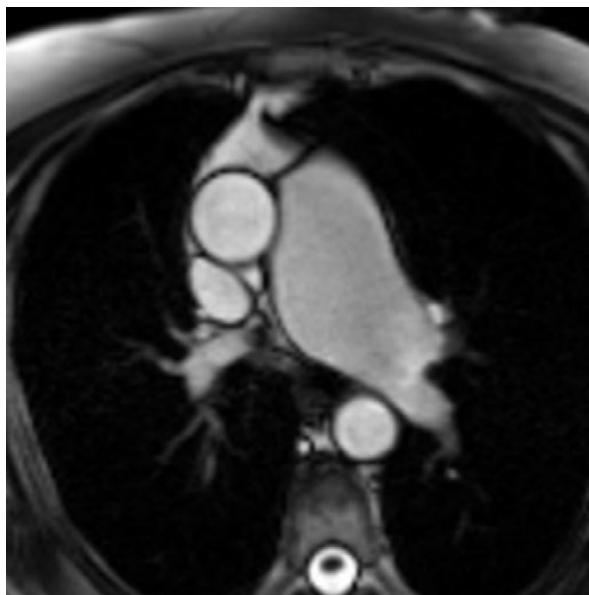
Cardiac magnetic resonance image (steady-state free precession sequence in axial view) shows the aneurysmal, dilated main pulmonary artery.
